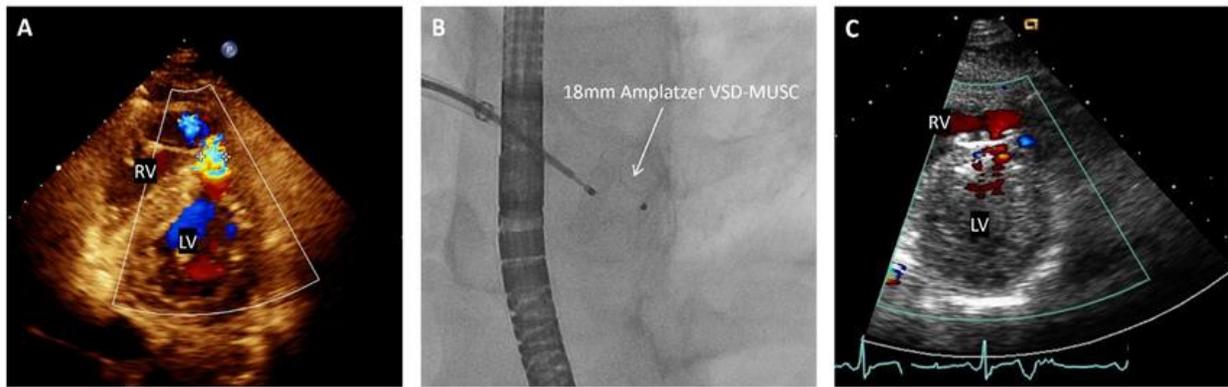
(A) An off-axis apical view from the pre-operative echocardiogram demonstrating a left to right shunt through the traumatic VSD. (B) Fluoroscopic still image of the successfully deployed 18mm Amplatzer VSD-MUSC device. (C) A parasternal short view from the 1-month post-operative transthoracic echocardiogram with a small residual shunt around the device.
